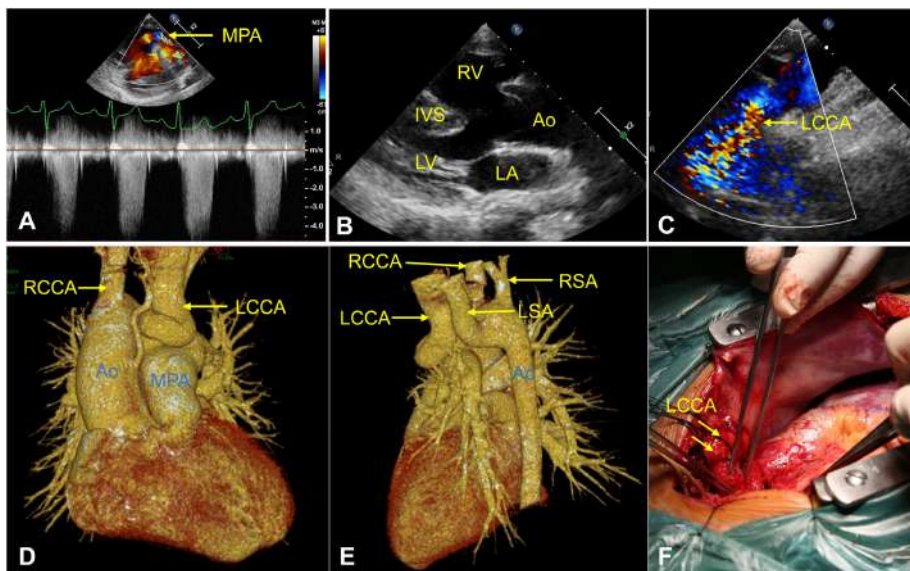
(A) Echocardiography showing severe pulmonary stenosis. (B) Echocardiography revealing ventricular septal defect and overriding of the aorta. (C) Color Doppler imaging demonstrating continuous blood flow within this vessel connecting to the main pulmonary artery. (D, E) Computed tomography angiography with 3D reconstruction reveals the anomalous origin of the left common carotid artery (LCCA) from the main pulmonary artery (MPA) and the right-sided aortic arch gives rise sequentially to the RCCA, RSA, LSA. (F) Intraoperative photograph showing the anomalous origin of the LCCA from the MPA. MPA, main pulmonary artery; LV, left ventricle; LA, left atrium; RV, right ventricle; IVS, Interventricular Septum; AO, aorta; LCCA, left common carotid artery; RCCA, right common carotid artery; RSA, right subclavian arteries; LSA, left subclavian arteries.
